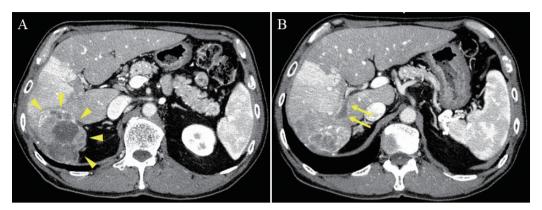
(A) Dynamic CT revealed a heterogenous low-density tumor in the posterior hepatic segments with rim enhancement during the portal phase (arrowheads). (B) Tumor thrombus in the right posterior portal vein was also observed (arrows).
